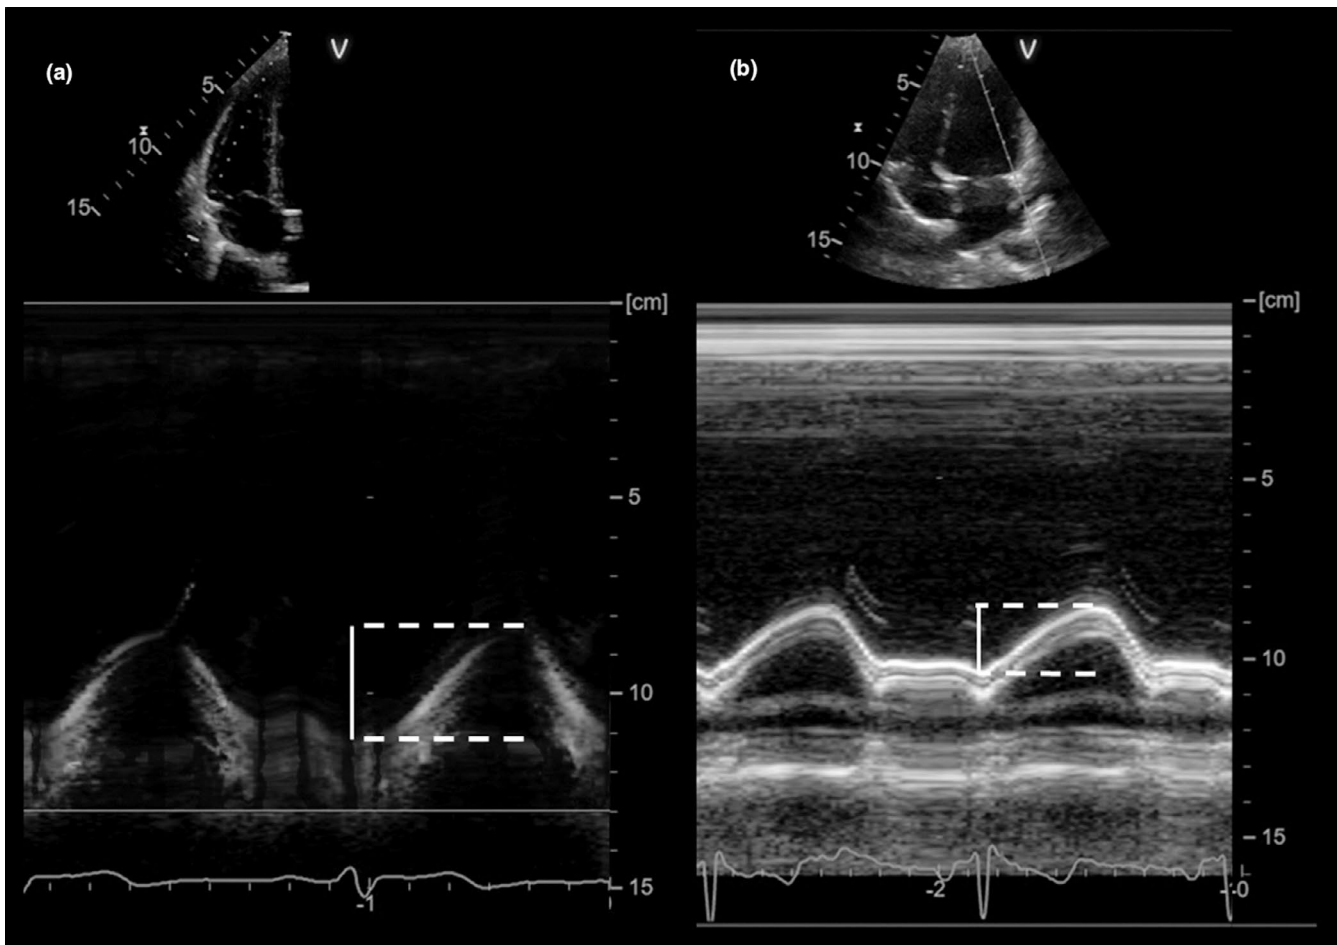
Mitral and tricuspid annular plane systolic excursion measurements by M-mode echocardiography. After visualization of the four-chamber view, M-mode is applied at the level of the lateral atrioventricular valve annulus. The distance from the lowest level at R-wave (end-diastole) to the highest displacement (end-systole) is measured for mitral annular plane systolic excursion (a; MAPSE) and tricuspid annular plane systolic excursion (b; TAPSE)
